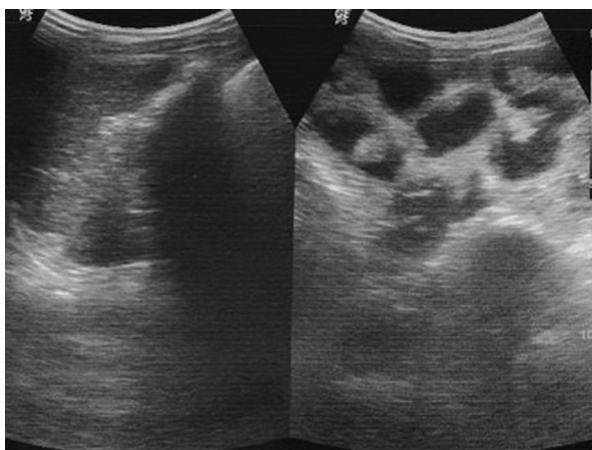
Abdominal ultrasound showing intestinal dilation below the liver, in the interposed loop topography.
